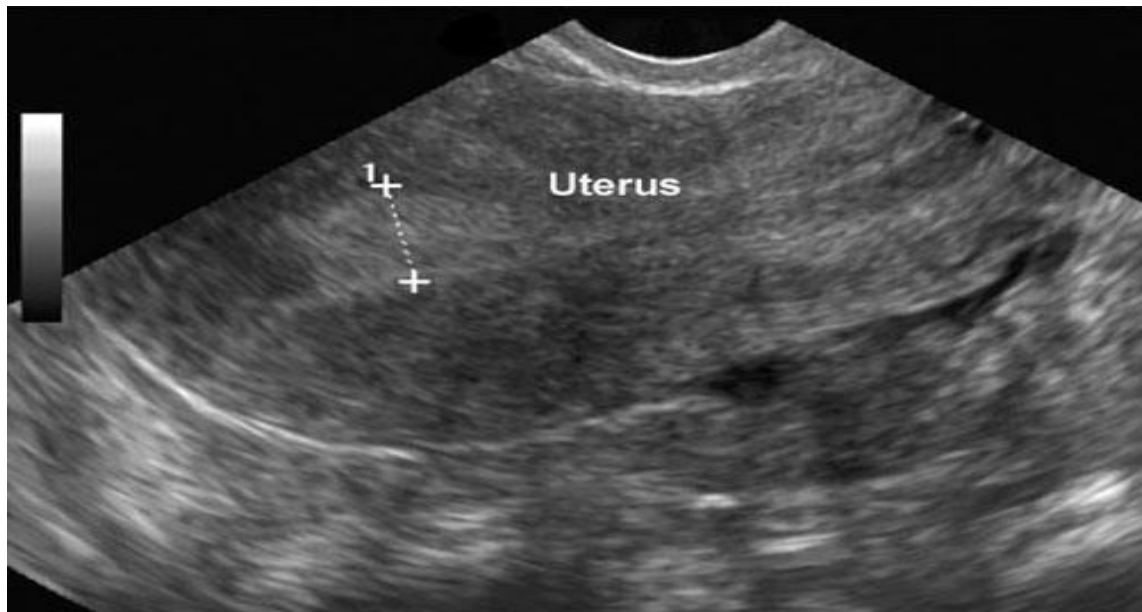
Measurement of uterine size and endometrial thickness by transvaginal ultrasound.
